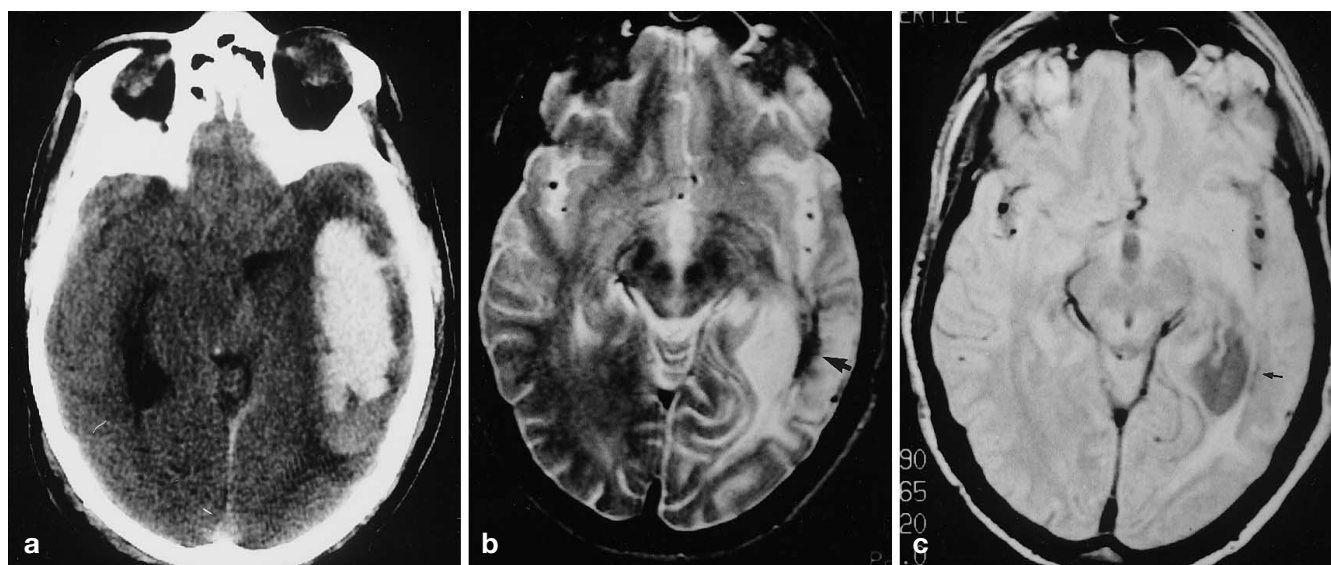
A well-defined, large, dense, temporal haematoma which “persisted”. a CT at 6 h; b,c T2- and PD-weighted MRI 1 year after injury. Note obvious black haemosiderin in b (arrow), just visible in c (arrow)
